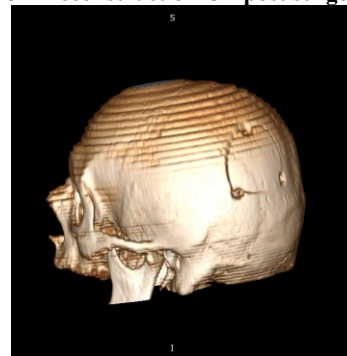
3D Reconstruction CT post surgery
